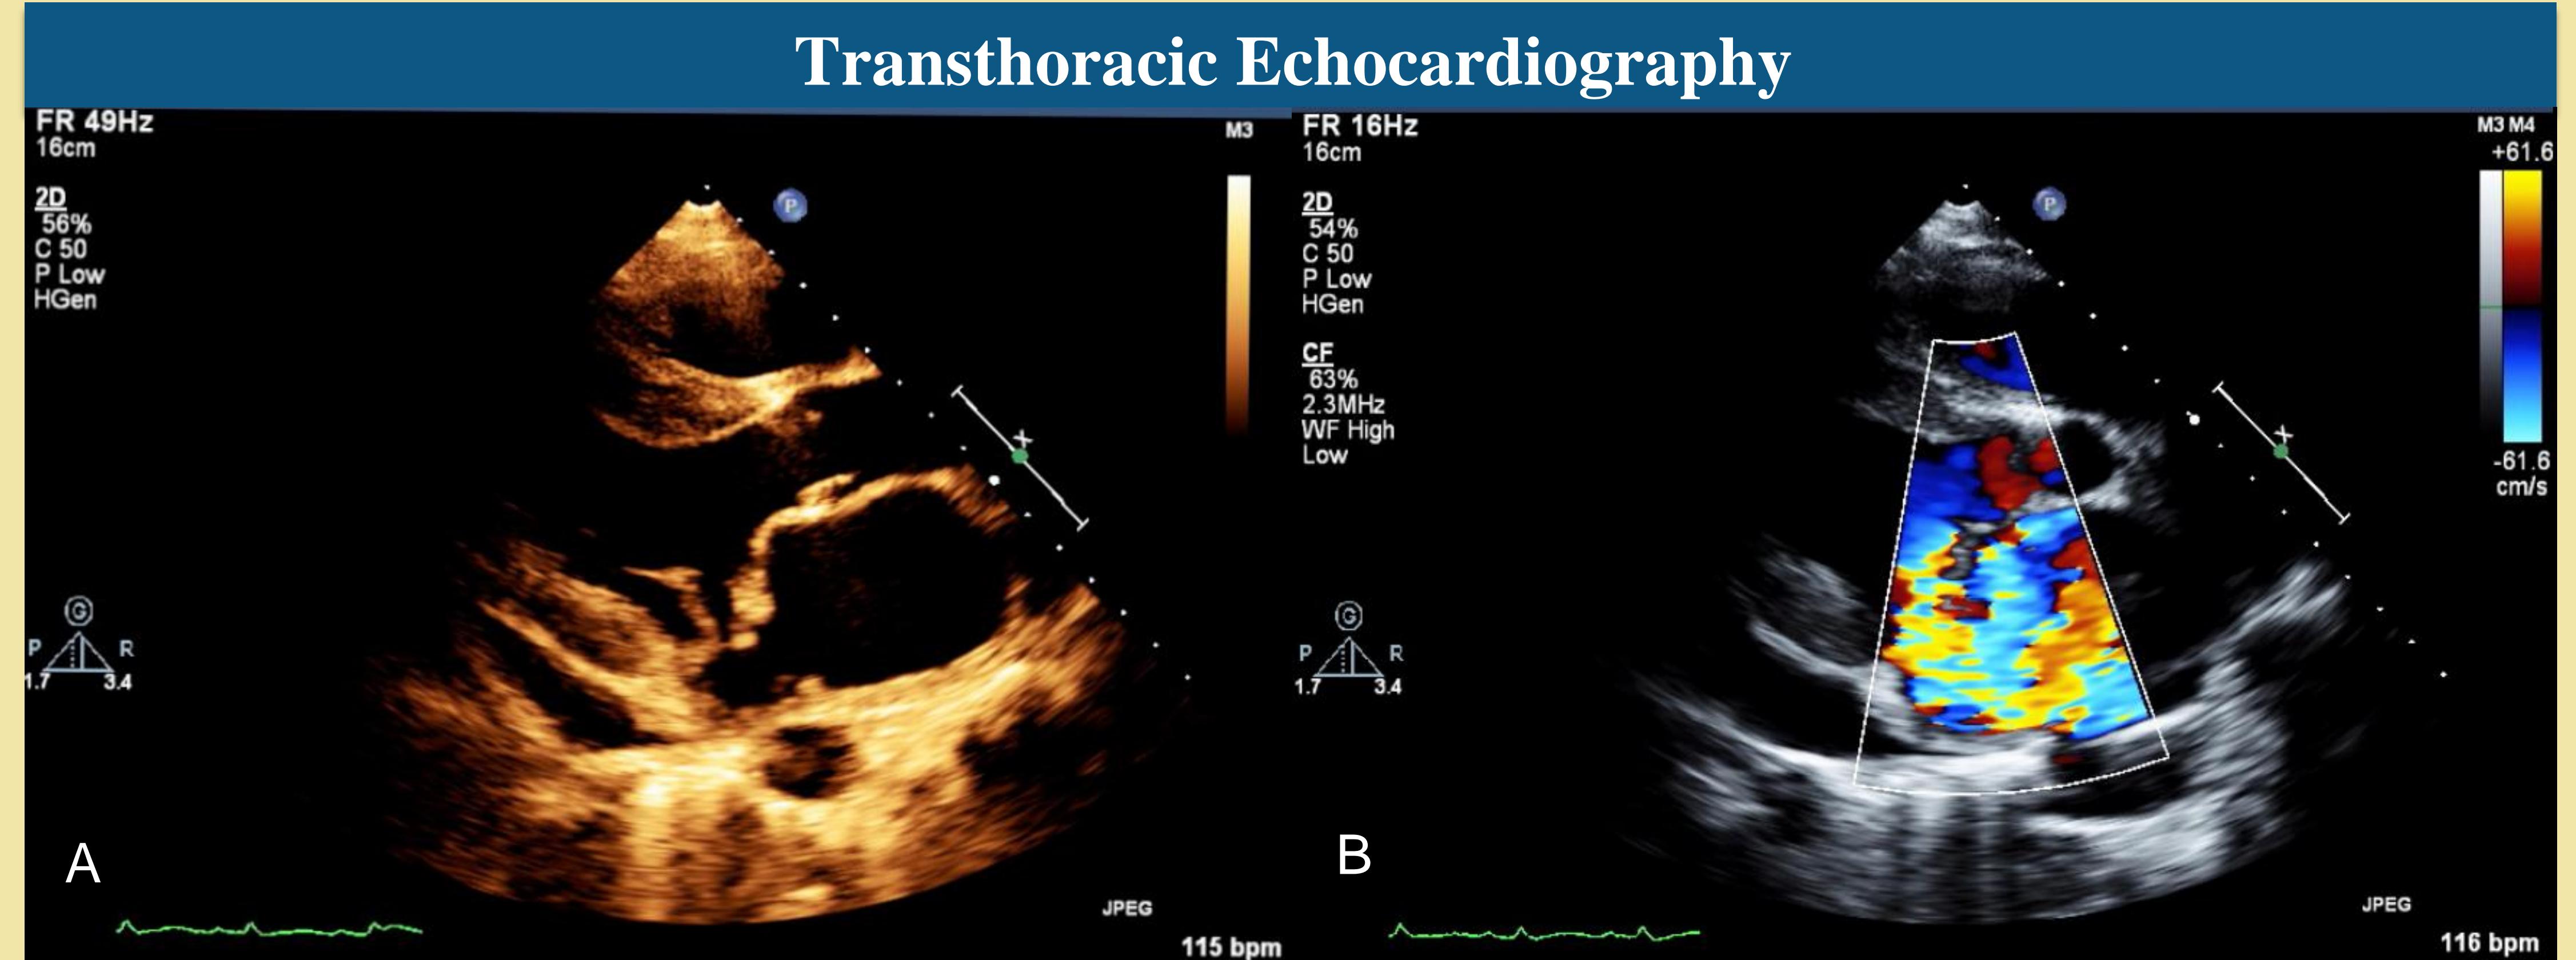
An emergent transthoracic echocardiogram demonstrated a dilated left ventricle, LVEF of 55-60%, severe MR with (A) a flail anterior leaflet and (B) posterolaterally-directed eccentric jet
